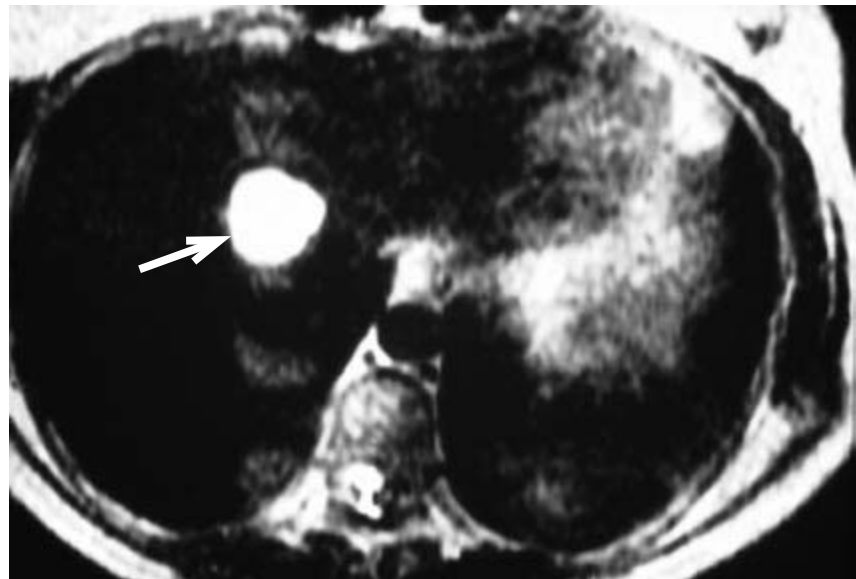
Haemangioma. MRI using long T_2 -weighting shows a very bright lesion (arrow). This reflects a profuse and very sluggish circulation usually due to a haemangioma.
